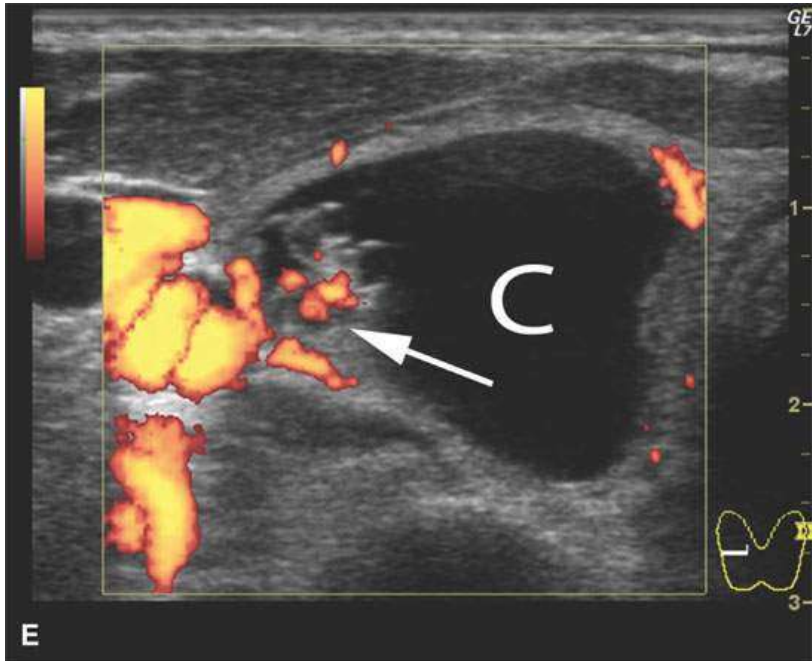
Patient with an enlarging low neck mass imaged first with ultrasound and then magnetic resonance imaging showing a cyst (C) and associated nodule in all of the following images. A: T1-weighted non-contrast-enhanced image showing a high signal intensity cyst suggesting that it contains colloid or blood products associated with a nodule (*arrow*). B: T2- weighted image shows the cyst to be of very low signal intensity suggesting the presence of blood products or desiccated colloid, but fibrosis or calcification would not seem to be reasonable alternative explanations based on all of the imaging findings. C: T1-weighted fat-suppressed contrast-enhanced magnetic resonance image shows that the cyst wall does not enhance and that the nodule is irregular and obviously vascularized. D: Comparison transverse B-mode ultrasound. E: Color flow ultrasound image shows that the nodule is not only irregular but also well vascularized.
